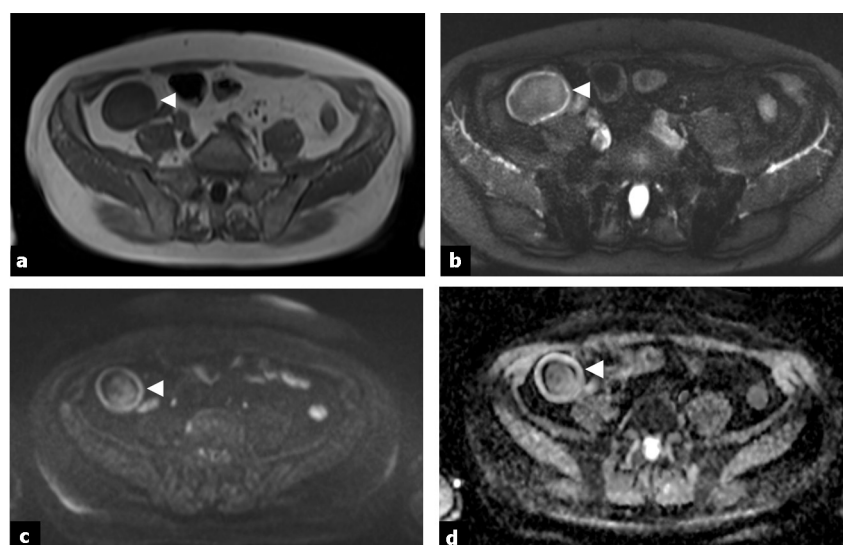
Axial abdominal MRI slices through the small bowel tumor lesion (white arrow) showing it as a T1-weighted homogeneous isointensity relative to the muscular tissue (a: T1-weighted FLASH 2D in/out of phase [TR = 140 ms, TE = 4.8/2.4 ms]), as a central T2-weighted hypointensity with a hyperintense peripheral ring (b: T2-weighted HASTE SPAIR [TR = 1180 ms, TE = 84 ms]), and as a roundel on the diffusion sequence (c: TR = 3300 ms, TE = 77 ms, b = 100, 400, 800) and ADC map (d).
